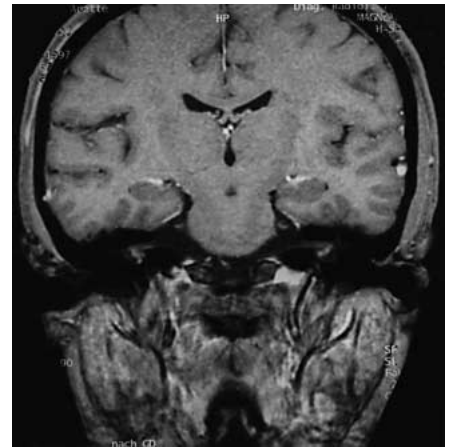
Postcontrast coronal T1-weighted MRI scan (TR 286, TE 18) confirms the finding of pericochlear enhancement.
